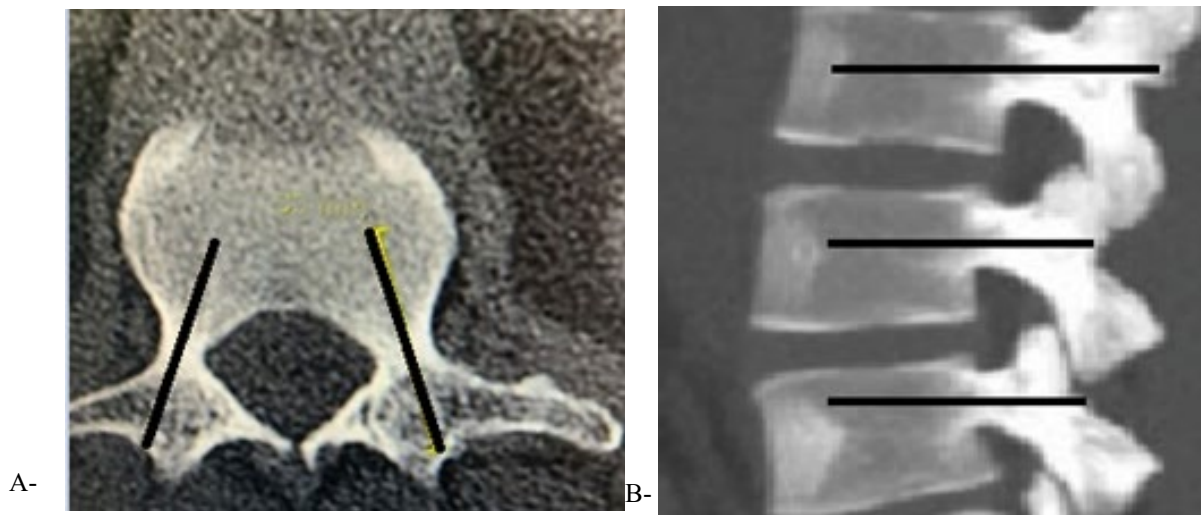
An axial and coronal CT of the lumbar spine (A, B) shows the correct entry points and screw direction inside the pedicle and the vertebral body (no different angulation at each level).
